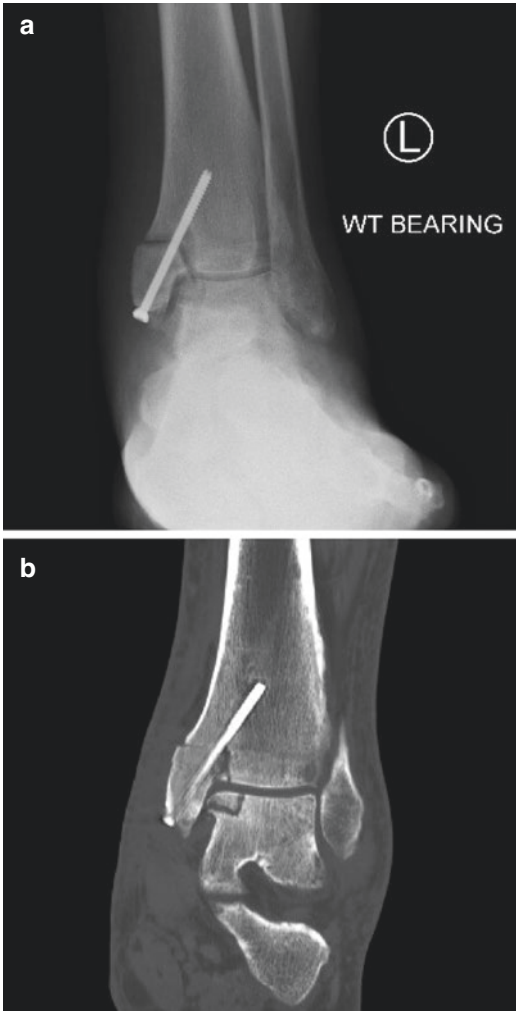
Radiographs (a) demonstrate a nonunion of a prior medial malleolar osteotomy. A lucency is visible at the site of the medial talar osteochondral allograft, but it is unclear if it has united. (b) CT scan confirms nonunion of both the medial malleolus and the talar allograft
